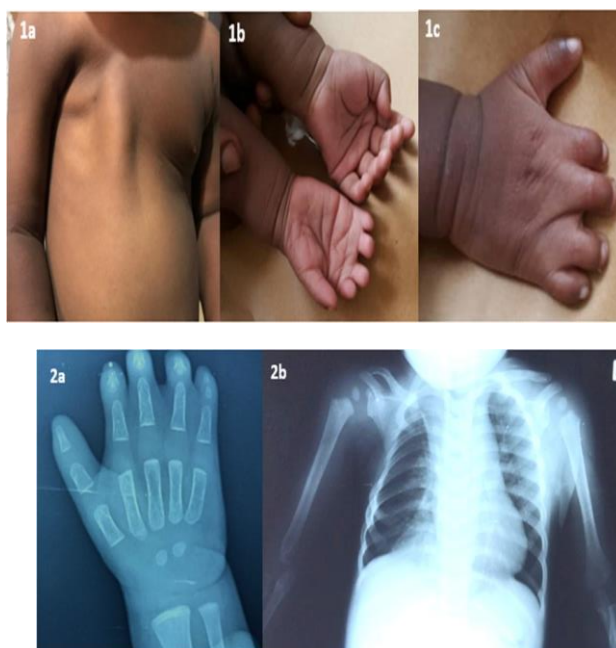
X-Rays of the Right Hand and the Chest
